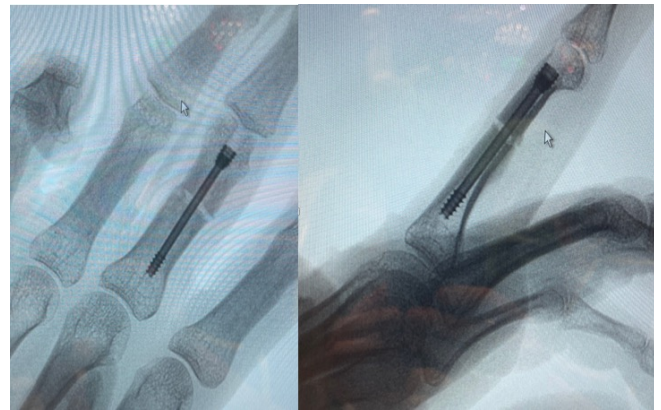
Postoperative radiographs. Intramedullary screw in the proximal phalanx.
